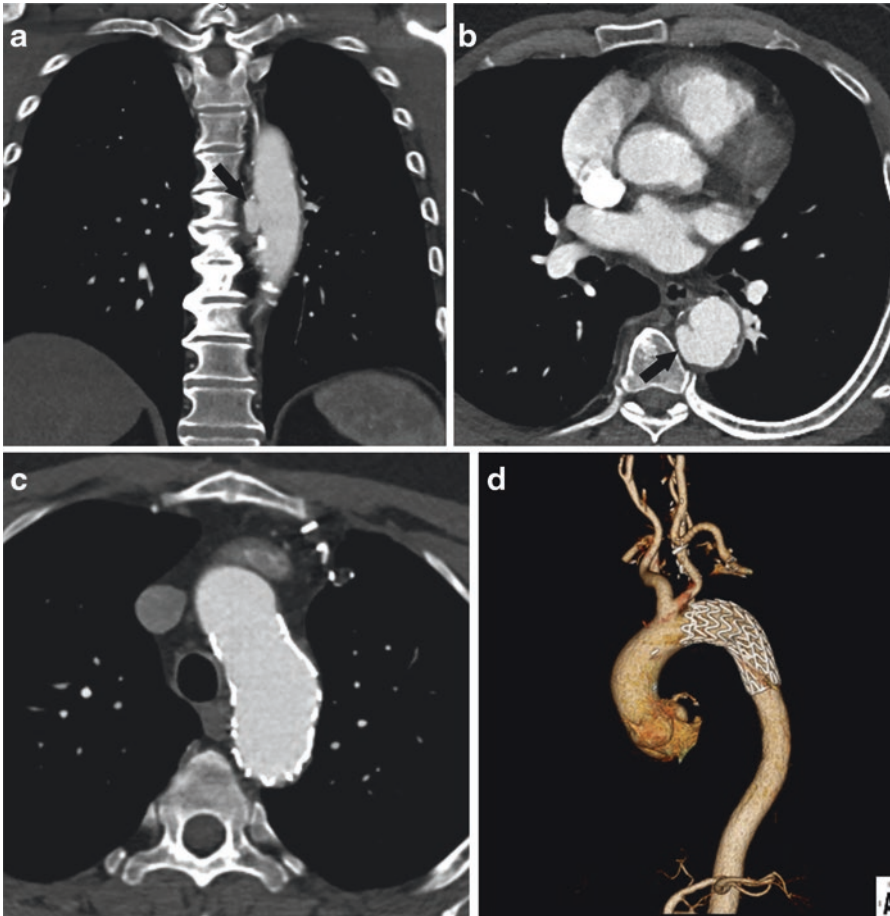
60-year-old man with a known history of penetrating atherosclerotic ulcer, presenting as an outpatient for presurgical planning. Coronal (a) and axial (b) CT angiogram demonstrates a focal penetrating atherosclerotic ulcer
